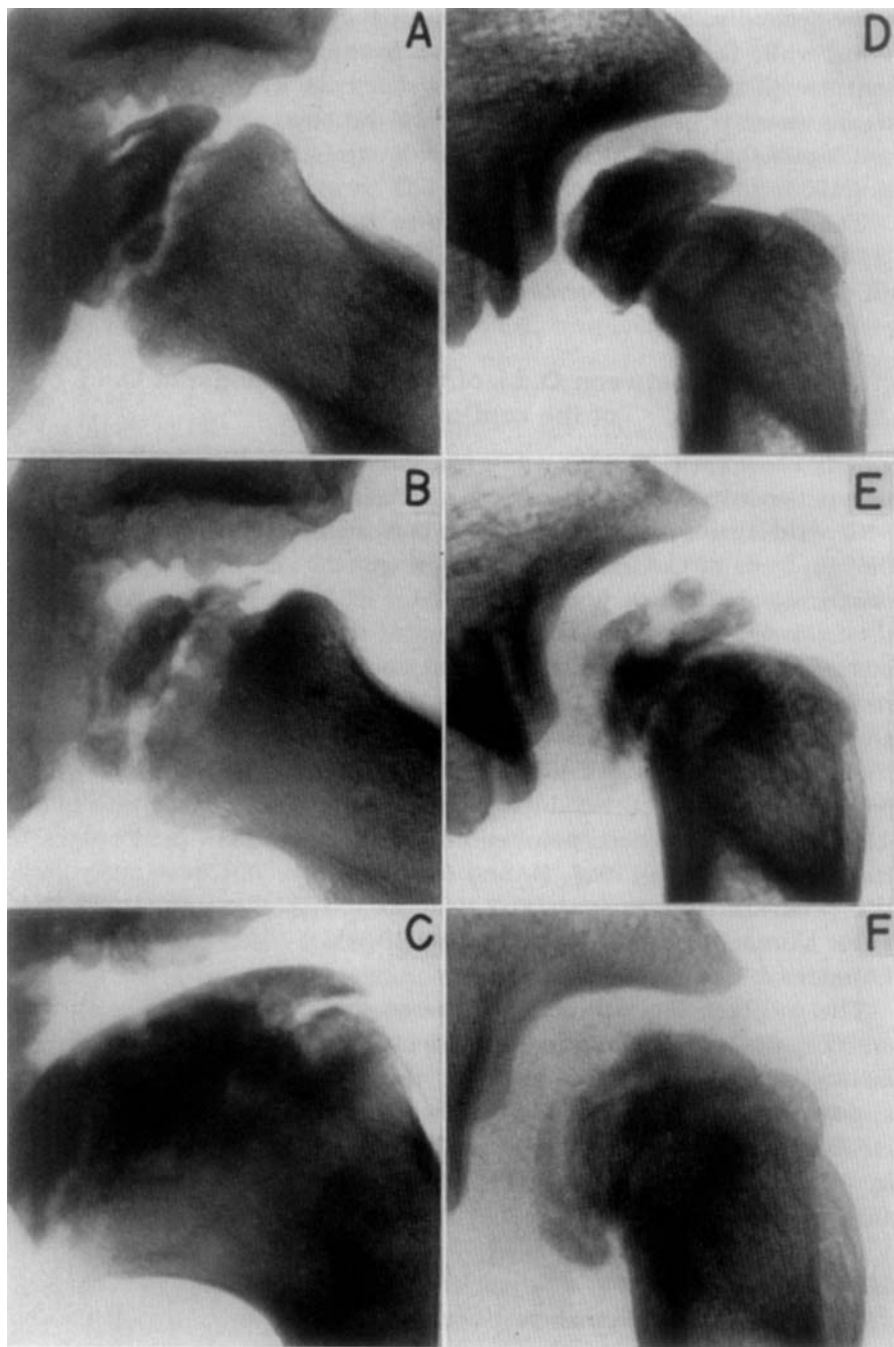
The roentgenologic similarity between O.d.j. capitis femoris (Legg-Calvé-Perthes disease), Figs. A, B, C and the process in capitulum humeri, Figs. D, E and F.
